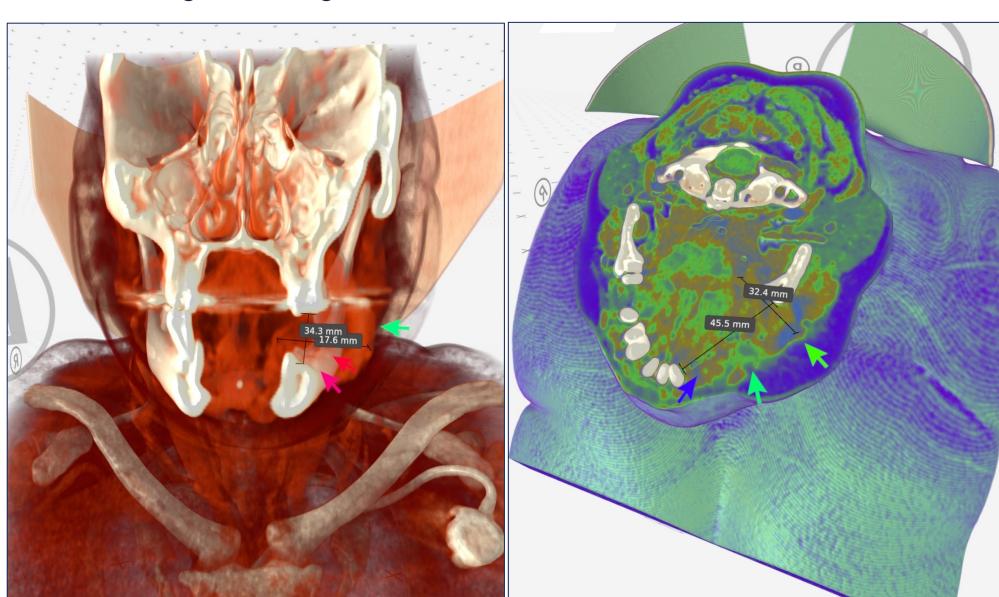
Pre-Operative CT Neck of patient from Figure 1a rendered as 3D Segmented Model on Medical Holodeck Software
